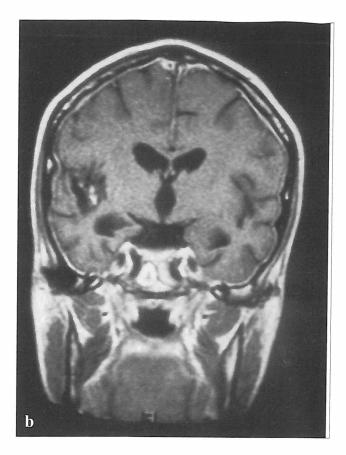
(a-b): HIV meningitis. Axial (a) and coronal (b) T1 weighted postcontrast MR images in an HIV positive patient demonstrate enhancement of pachymeninges suggestive of HIV meningitis. Generalized cortical sulci atrophy is the sequelae of chronic HIV encephalitis.
